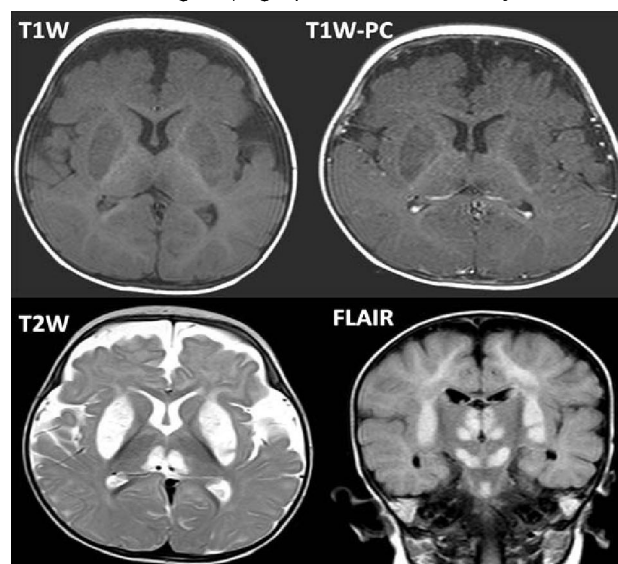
MRI brain images show bilateral symmetrical abnormal signal intensities involving basal ganglia, thalami, cerebral peduncles, dorsal medulla and peri-aqueductal grey matter appearing hyperintense on T2W, FLAIR and DW images. No significant enhancement was seen in post contrast study (T1W-PC).
